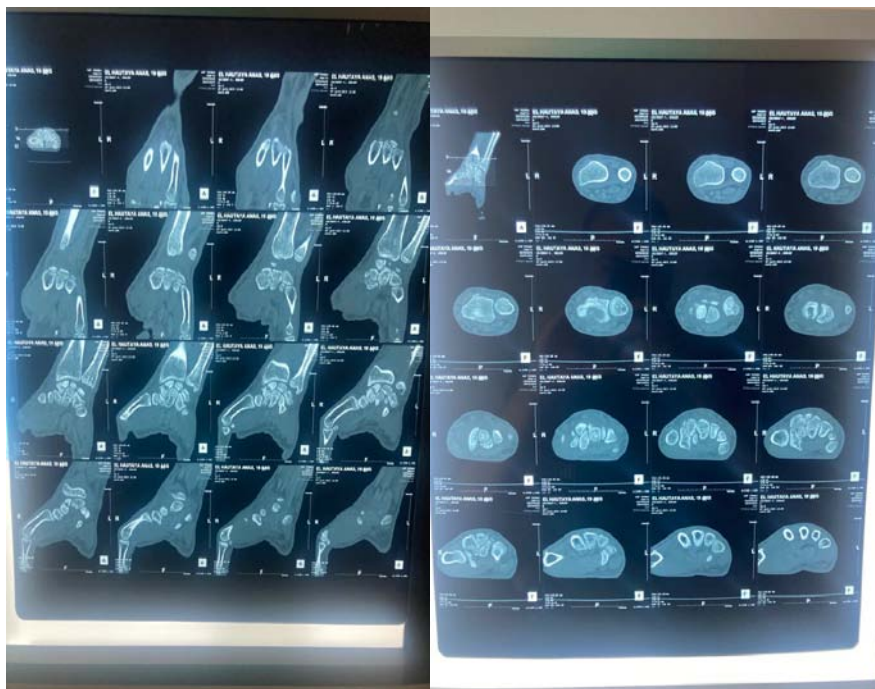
The computed tomography (CT) scan confirmed the scaphoid fracture and the localized and non-aggressive nature of the cyst.
